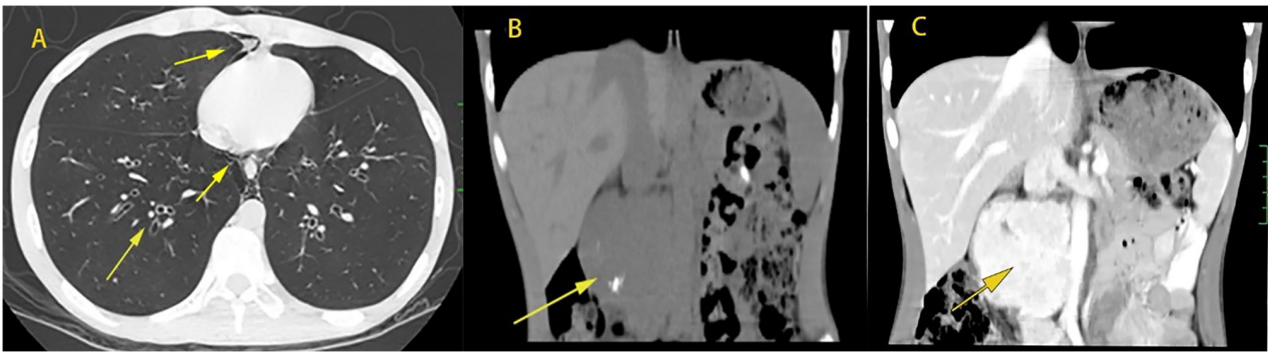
Case 1. 64-slice spiral CT, June 2009. (A) On a plain scan of the lung window, a patchy shadow of increased density is visible in the anterior segment of the right upper lobe (upper right arrow). Endogenous gas was present in the mediastinum and posterior chest wall (lower right arrow) and bronchiectasis (lower left arrow) was seen in both lungs. (B) On a plain scan, the density of the right posterior abdominal mass was uniform. (C) On enhanced CT, the right posterior abdominal mass was significantly enhanced.
